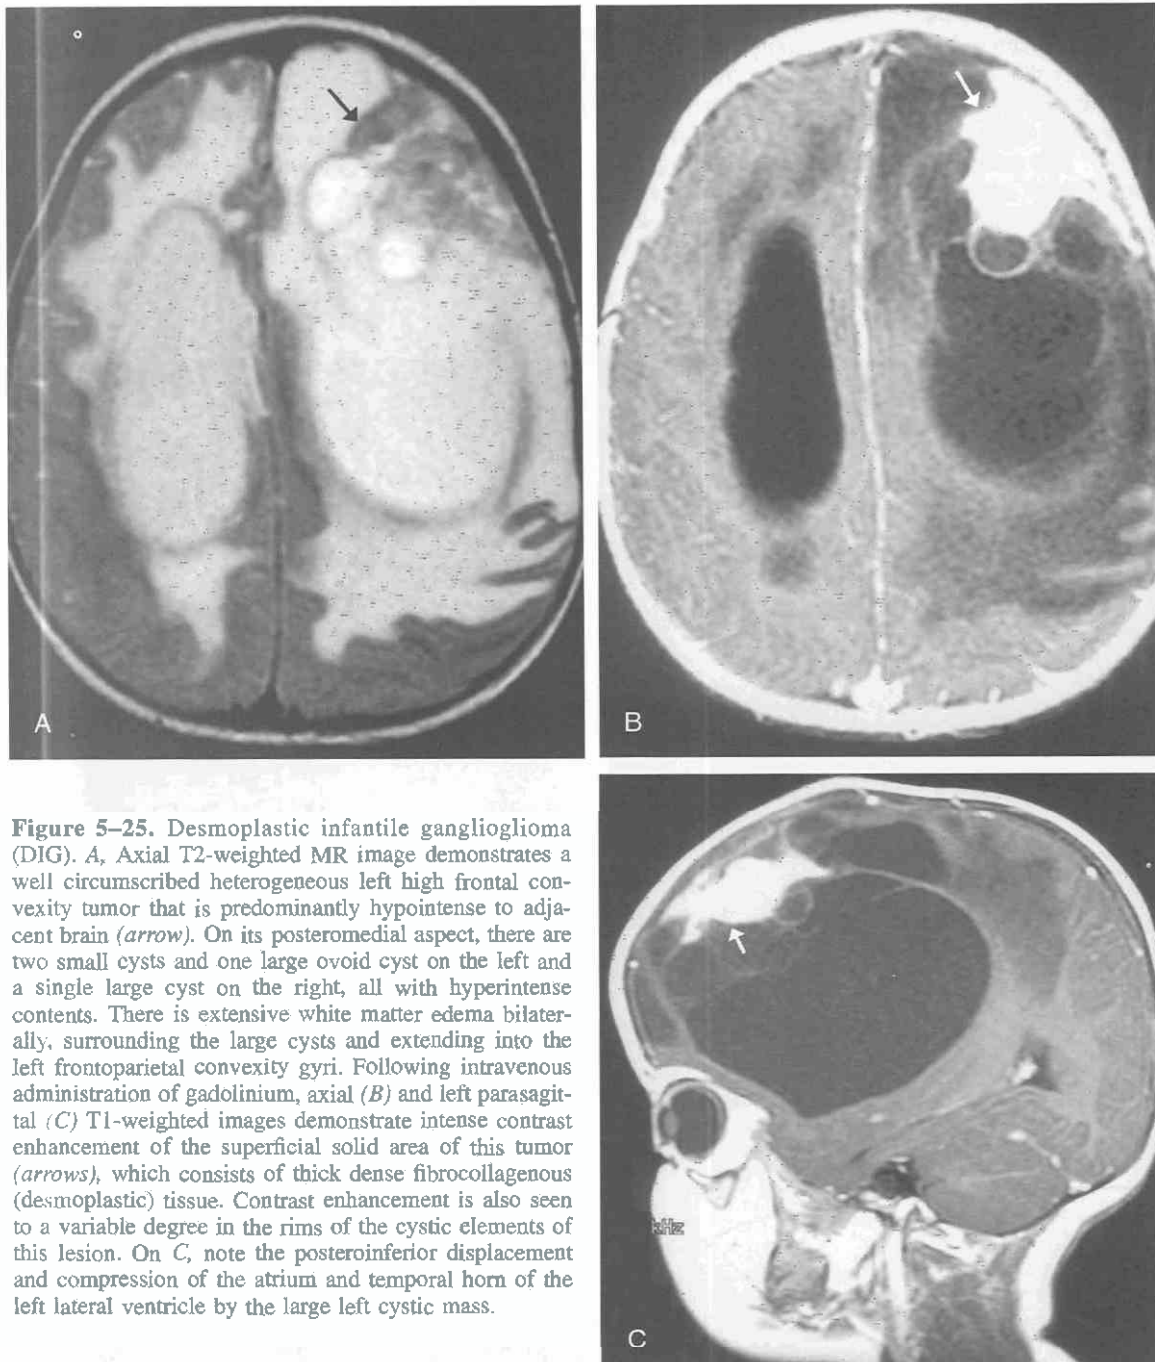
Desmoplastic infantile ganglioglioma (DIG). A, Axial T2-weighted MR image demonstrates a well circumscribed heterogeneous left high frontal convexity tumor that is predominantly hypointense to adjacent brain (arrow). On its posteromedial aspect, there are two small cysts and one large ovoid cyst on the left and a single large cyst on the right, all with hyperintense contents. There is extensive white matter edema bilaterally, surrounding the large cysts and extending into the left frontoparietal convexity gyri. Following intravenous administration of gadolinium, axial (B) and left parasagittal (C) T1-weighted images demonstrate intense contrast enhancement of the superficial solid area of this tumor (arrows), which consists of thick dense fibrocollagenous (desmoplastic) tissue. Contrast enhancement is also seen to a variable degree in the rims of the cystic elements of this lesion. On C, note the posteroinferior displacement and compression of the atrium and temporal horn of the left lateral ventricle by the large left cystic mass.
